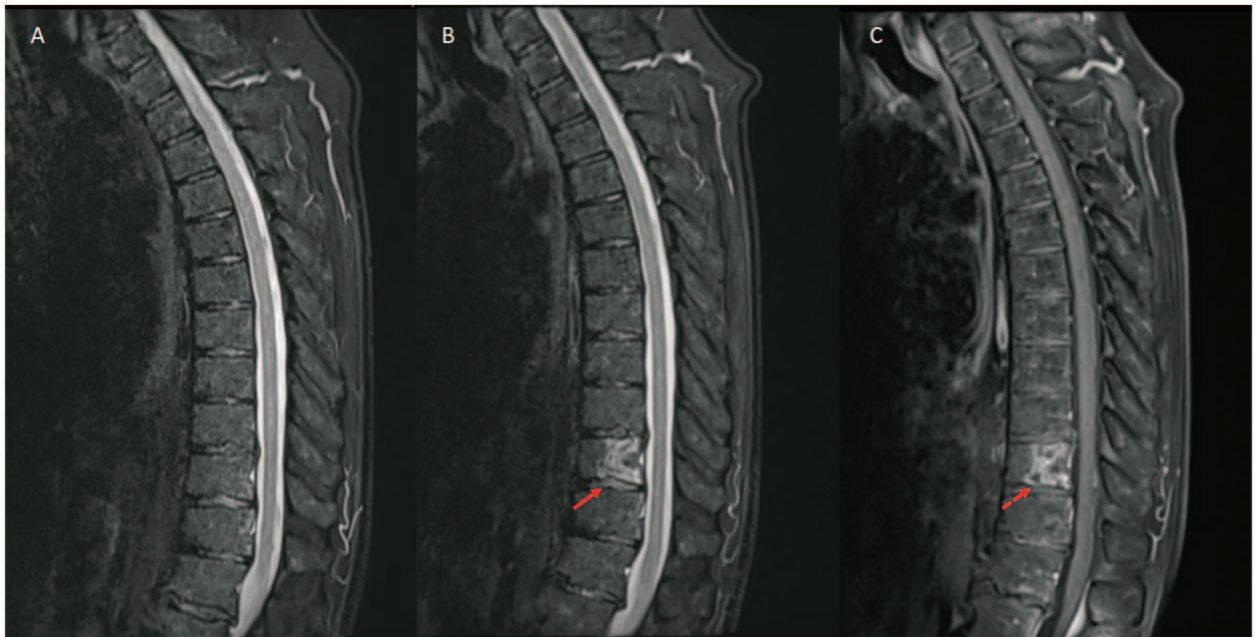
MRI of the spinal cord showing initial (a) and follow-up images after three weeks (b, c). A. Sagittal T2 weighted STIR image revealing normal signal of the thoracic vertebra. B. Sagittal T2 weighted STIR image demonstrating hyperintensity of the dorsal part of the Th10 vertebra (red arrow). C. Sagittal T1 weighted post-contrast image demonstrating gadolinium enhancement of the dorsal part of the Th10 vertebra (red dotted arrow). STIR-short-tau inversion recovery.
